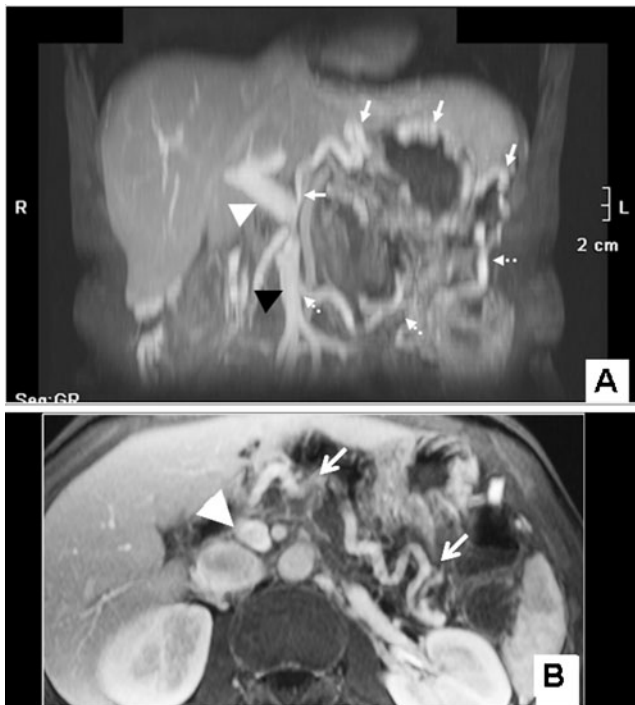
Patient 2. Postcontrast, fat suppressed, T1 weighted magnetic resonance images. Two venous collateral systems are shown. a Coronal image. The superior route (solid arrows) passed from the splenic vein around and through the stomach to enter the portal vein (white arrowhead) via the coronary vein. The inferior route (dotted arrows) passed from the splenic veins through the root of the mesentery to the superior mesenteric vein (black arrowhead). b Transverse image. The inferior route (arrows) is seen better in the transverse view. The white arrowhead is the superior mesenteric vein
